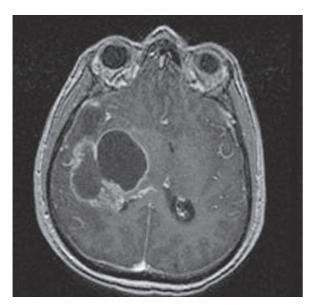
Contrast-enhanced, T1-weighted MRI demonstrating classic radiographic signs of a GBM. A central area of low attenuation (necrosis) with multifocal and rim enhancement (active tumor) can be seen infiltrating the corpus callosum and is associated with mass effect and diffuse edema
